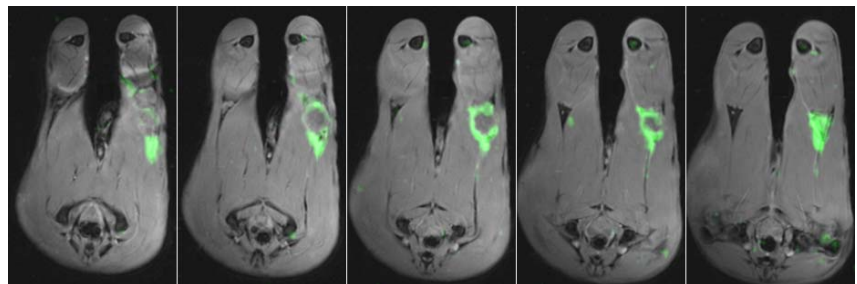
3D imaging of a Vx-2 tumor at an in-plane resolution of 2.19 mm (slice thickness 4 mm): 5 adjacent image planes out of 15 are shown. Simultaneous ^{19}F and ^1H acquisition was completed within 35 minutes. Anatomical co-registration is demonstrated by overlay of ^{19}F (green) and high-resolution T1-weighted ^1H GRE images.
